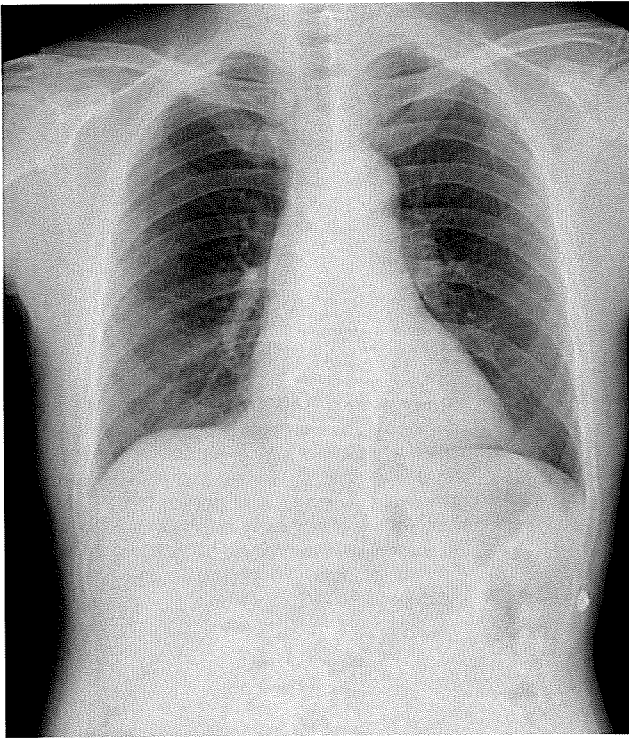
Chest x-ray showed mild cardiac enlargement.
